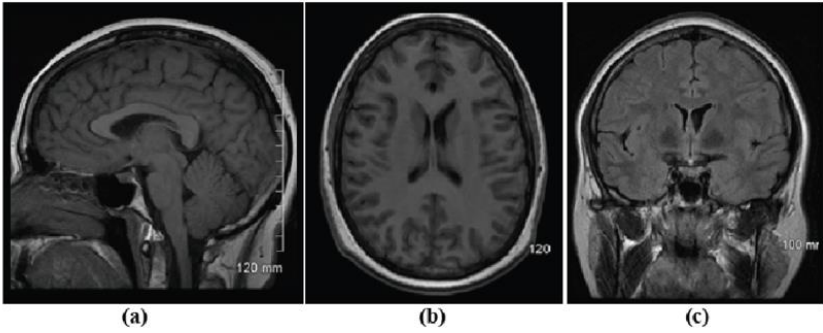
Brain MRI in (a) Sagittal Plane (b) Axial Plane and (c) Coronal Plane
